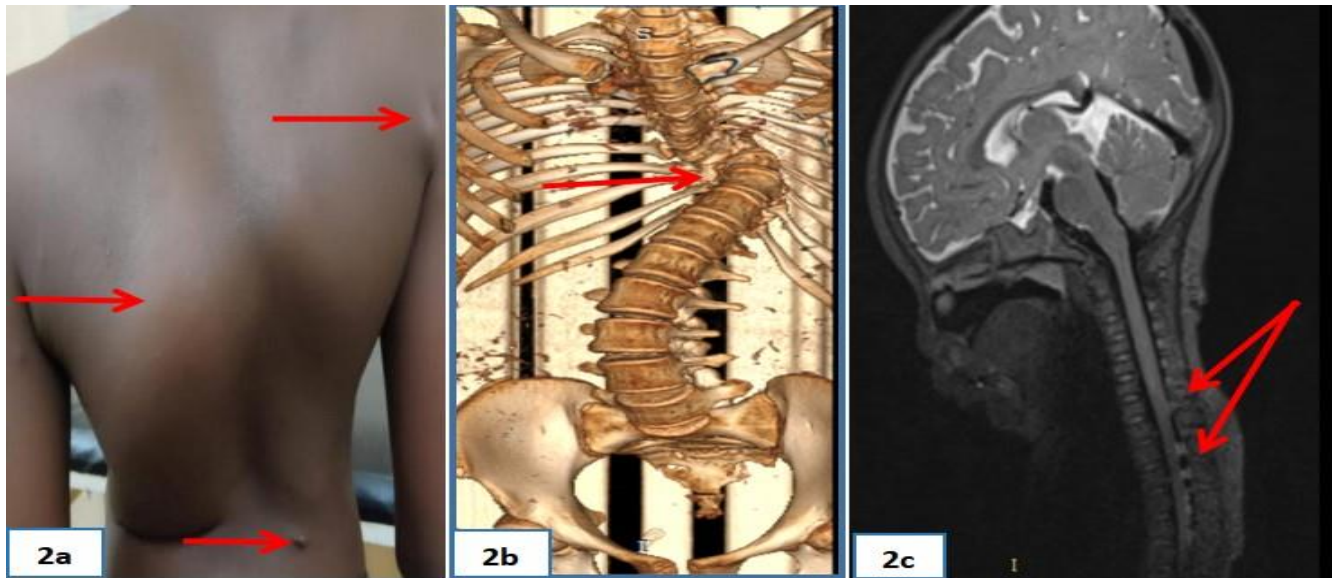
(2a) Photograph showing dorsal scoliosis, a left dorsal gibbosity and a cutaneous neurofibroma located on the dorsal right shoulder. (2b):CT scan of the spine in sagittal window section with 3D reconstruction showing scoliotic deformity of the dorsolumbar spine. (2c): MRI: sagittal T1 section showing nerve root involvement with plexiform neurofibromas in the 14-year-old patient.
